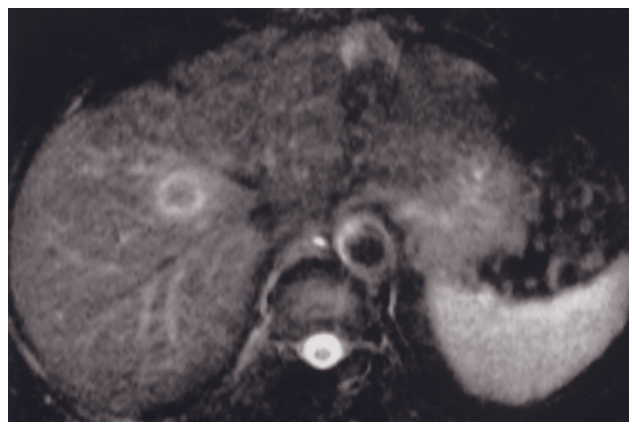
(*Continued*) on immediate postgadolinium image (*h*) and fades on late image (*i*). Note that the metastases are best seen on T2-weighted images (*f*) and not definable on late phase (*i*).
